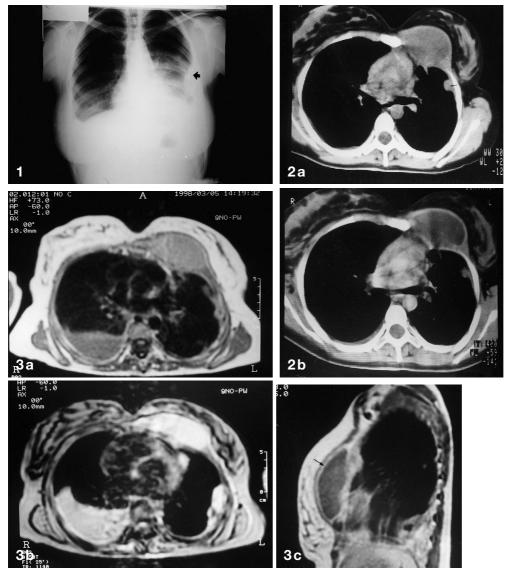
Chest radiograph shows a mass of homogeneous density (*arrow*) with a broad base suggesting an extrapleural mass
